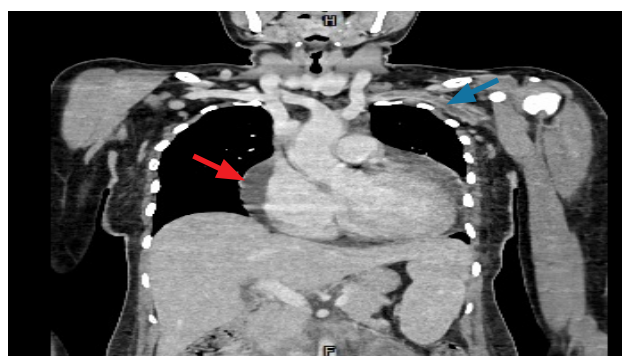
Coronal CT scan shows left axillary vein and left subclavian vein thrombosis (blue arrow) and pericardial effusion (red arrow).
